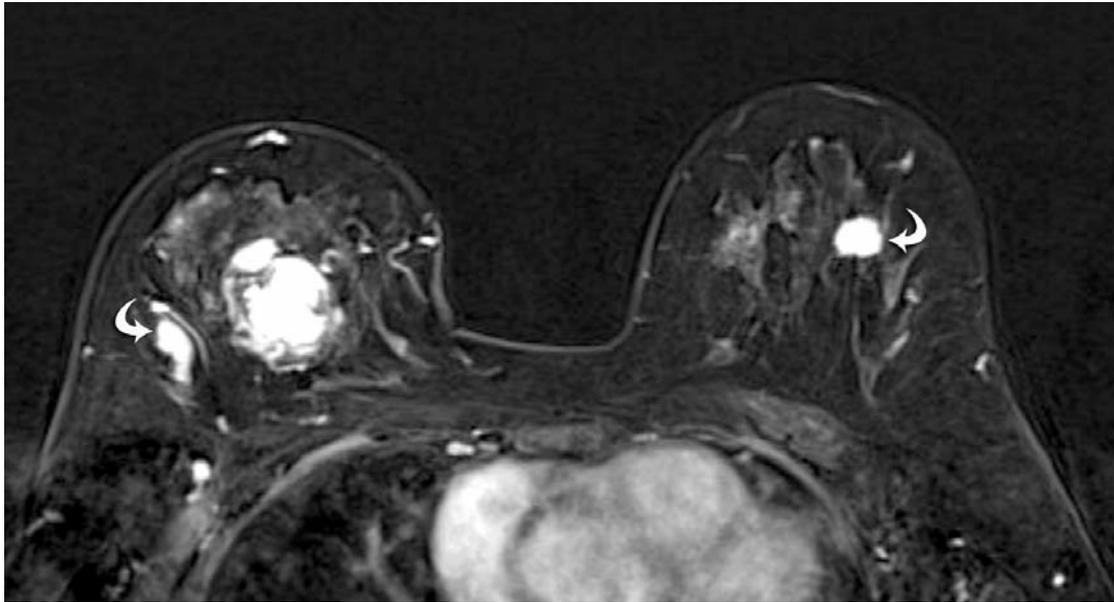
Early phase image of dynamic enhancement magnetic resonance imaging shows a 5-cm oval, smooth, heterogeneously enhancing mass in the upper quadrant of the right breast and synchronous bilateral breast carcinoma (curved arrows) in upper outer quadrant of both breasts.
